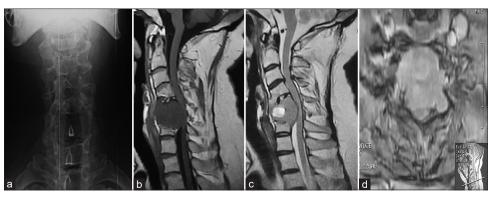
(a) Interpedicular and interspinous widening at C5, implementing large expansile lytic lesion replacing C5 vertebral body. Left C5 pedicle absent while right C5 pedicle displaced and thinned out. (b and c) Sagittal cervical spine magnetic resonance imaging showing soft-tissue mass isointense on T1 and T2, replacing C5 body, with T2 hyperintense cavity in the anterior part. (d) Axial section at C5 level, showing homogeneous enhancement of lesion, extension to the left pedicle, and thecal sac compression. Posterior elements are well spared
